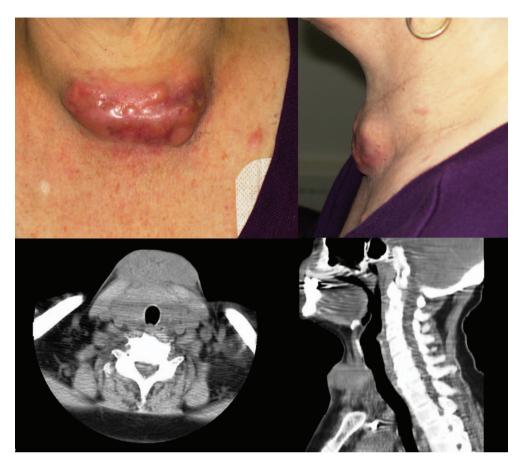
Patient's front and left profile (upper) and corresponding contrast-enhanced CT scans (lower) showing the subcutaneous chloroma located in the anterior aspect of the neck.
